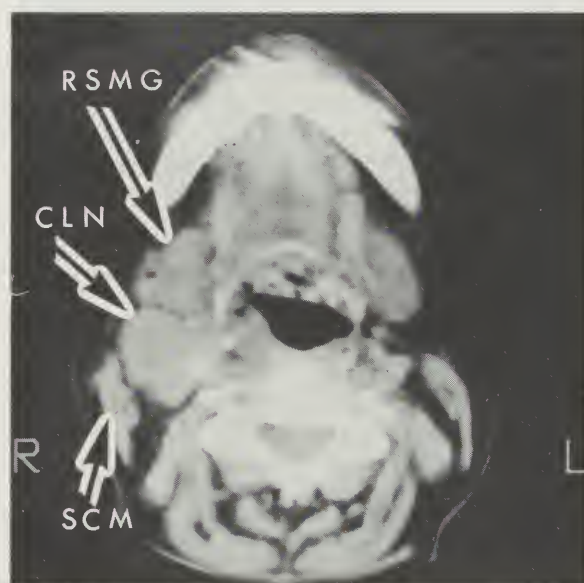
CT scan at lower level in the neck. Enlarged cervical lymph node (CLN) posterior to the right submandibular gland (RSMG) and medial to the sternocleidomastoid muscle (SCM).
